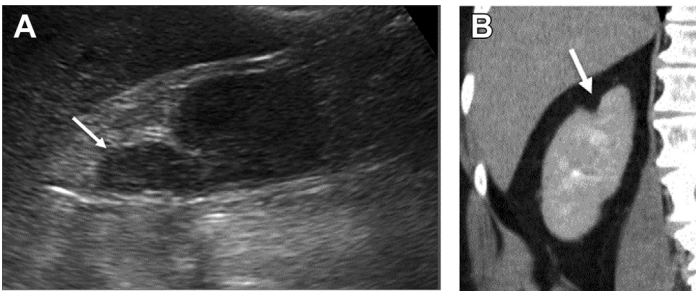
A 73-year-old man with urinary obstruction. (A) Sagittal ultrasound image of the right kidney shows bulbous protrusion from the upper pole of the kidney (*arrow*). (B) Coronal contrast-enhanced CT MPR image shows that the region represents normal parenchyma adjacent to a parenchymal scar (*arrow*).
